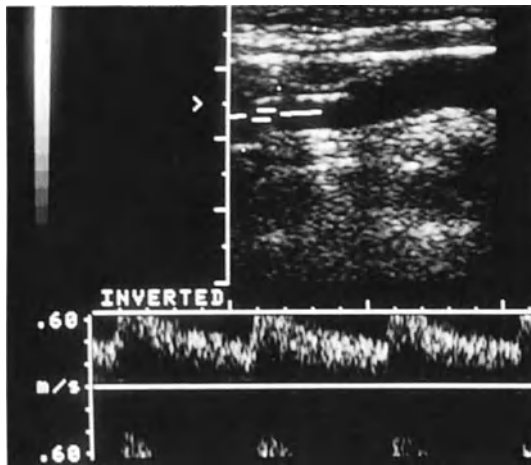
Aliasing in a duplex spectral tracing: the velocity scale is inadequate to accommodate the high frequency shifts present in the returning Doppler signal; as a result systolic peaks are “wrapped around” on the display
